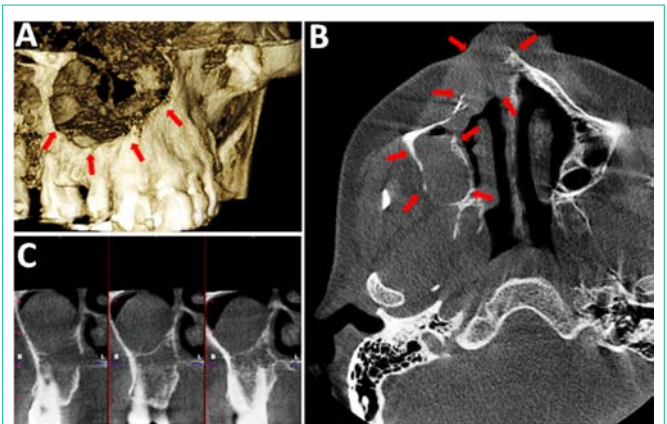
(a) 3-D reconstructed image showing perforation of buccal cortex and nasal cavity, (b) Axial CBCT scan shows the position of the lesion in proximity to nasal cavity and maxillary sinus, (c) Cross sectional CBCT image showing the lesion and its relation with right maxillary second and third molars (red arrows).
